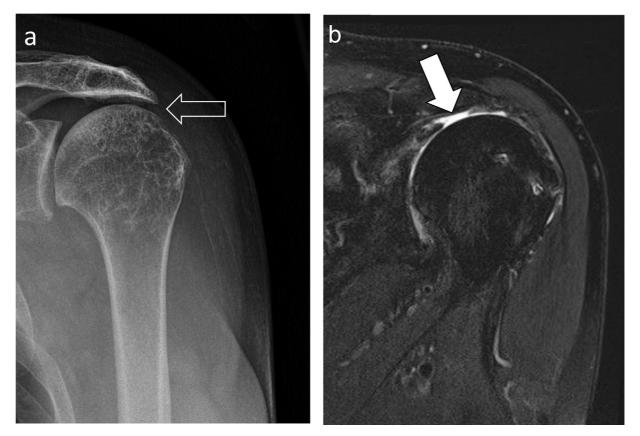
(a) Anteroposterior radiograph and (b) coronal T2 fat-sat sequence of the left shoulder demonstrating failed superior capsular reconstruction. The acromiohumeral interval (a, open arrow) showed progressive narrowing postoperatively, a finding that may suggest graft failure. The magnetic resonance image in (b) shows a focal defect (arrow) in the midsubstance of the graft with fluid traversing through this defect.
